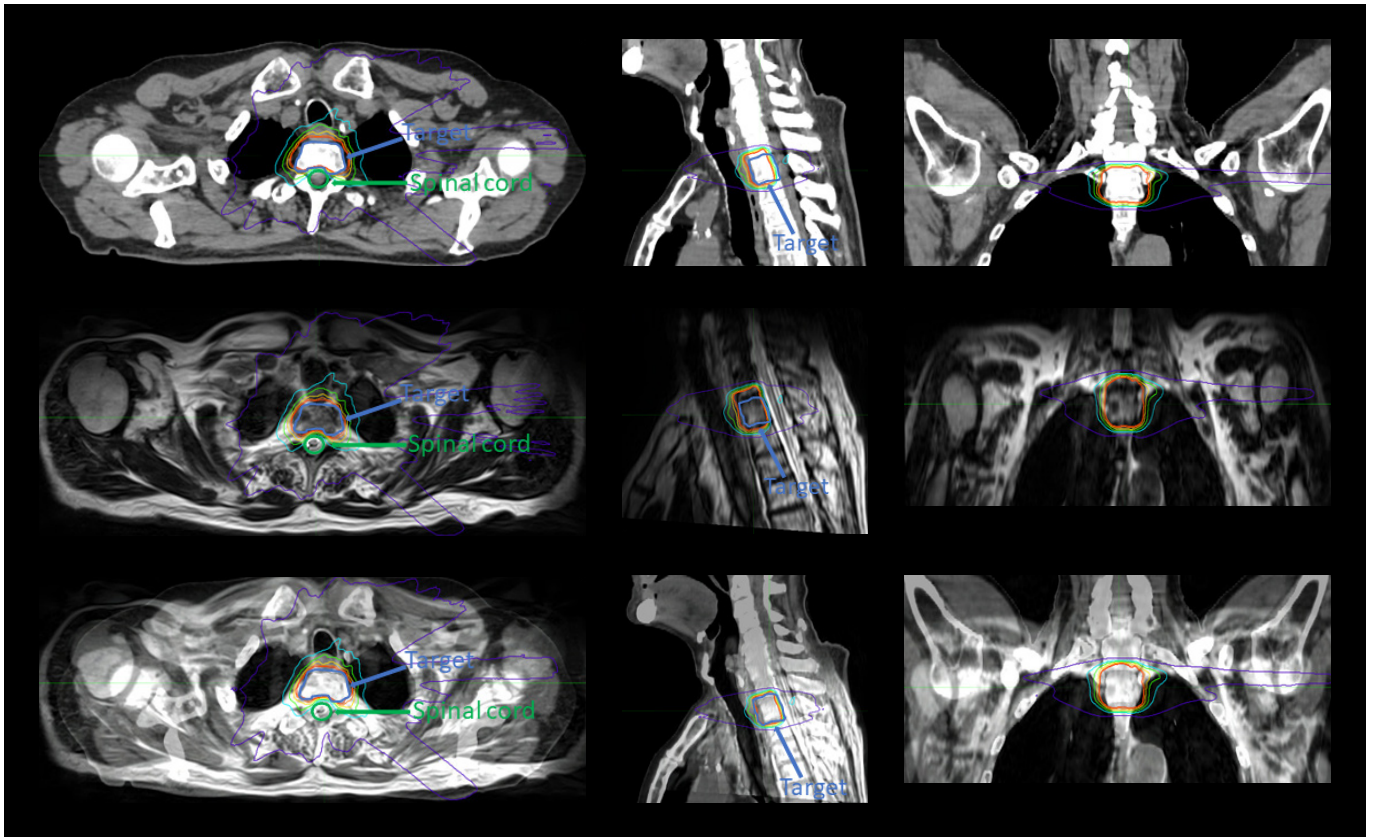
The dosimetry map on MRI, CT images, and the fusion of two modalities in three axes. The target and spinal cord are shown with arrows.
